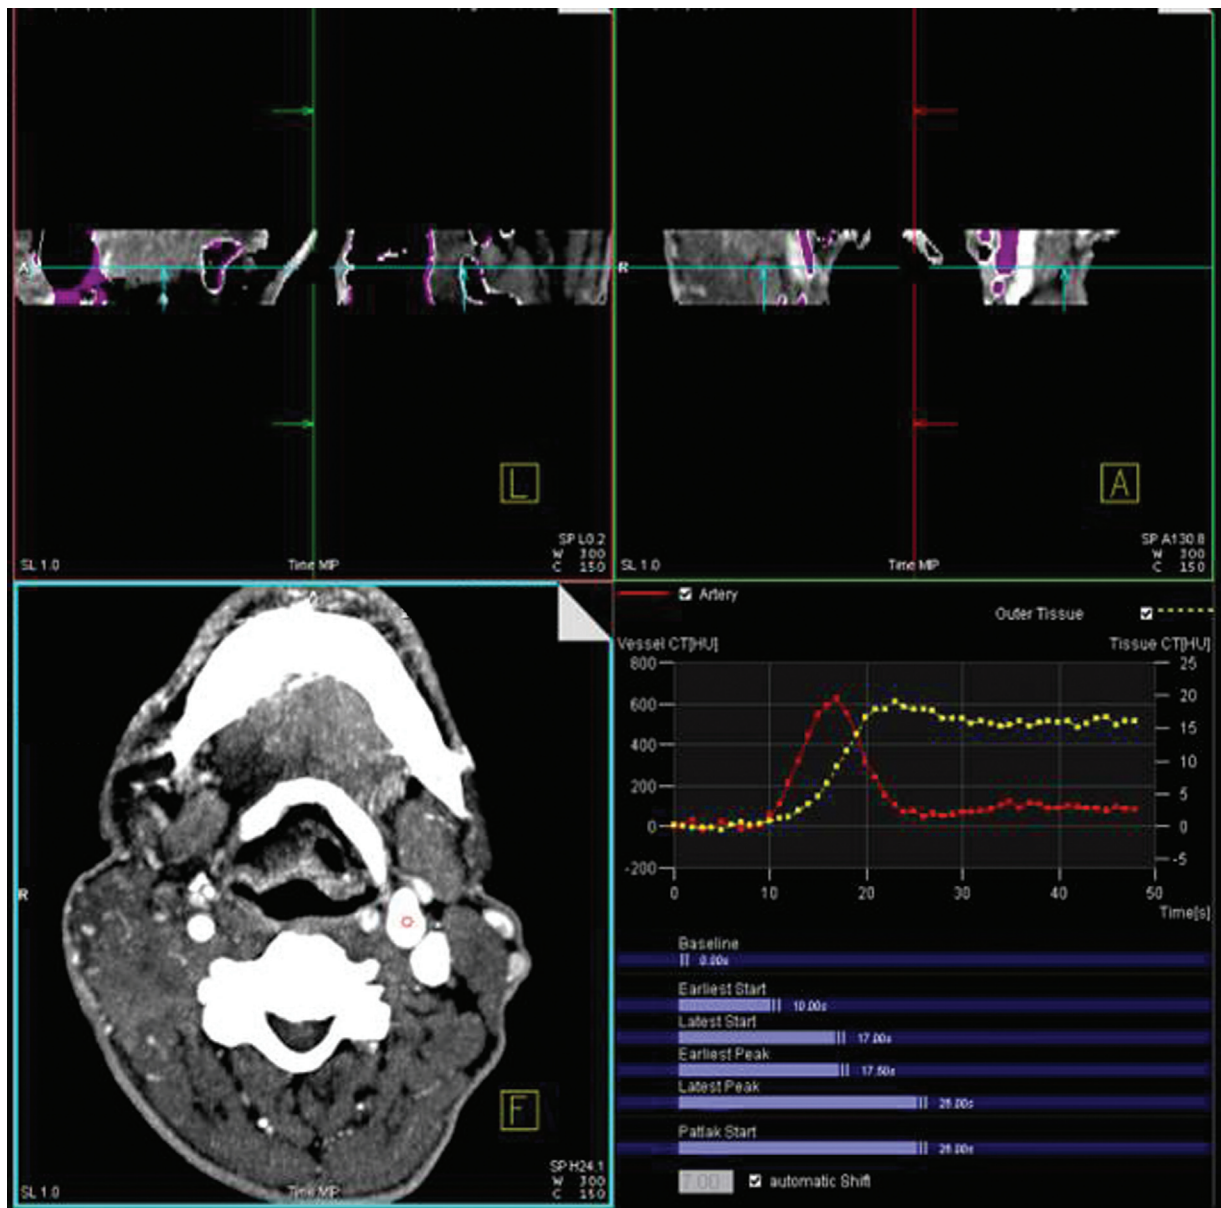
Placement of ROI in carotid artery and generation of time attenuation curve. The sample interval was 1 second and CT perfusion acquisition was done for 50 seconds. So the time attenuation curve has 50 sample points (SD). CT, computed tomography; ROI, region of interest; SD, standard dose.
